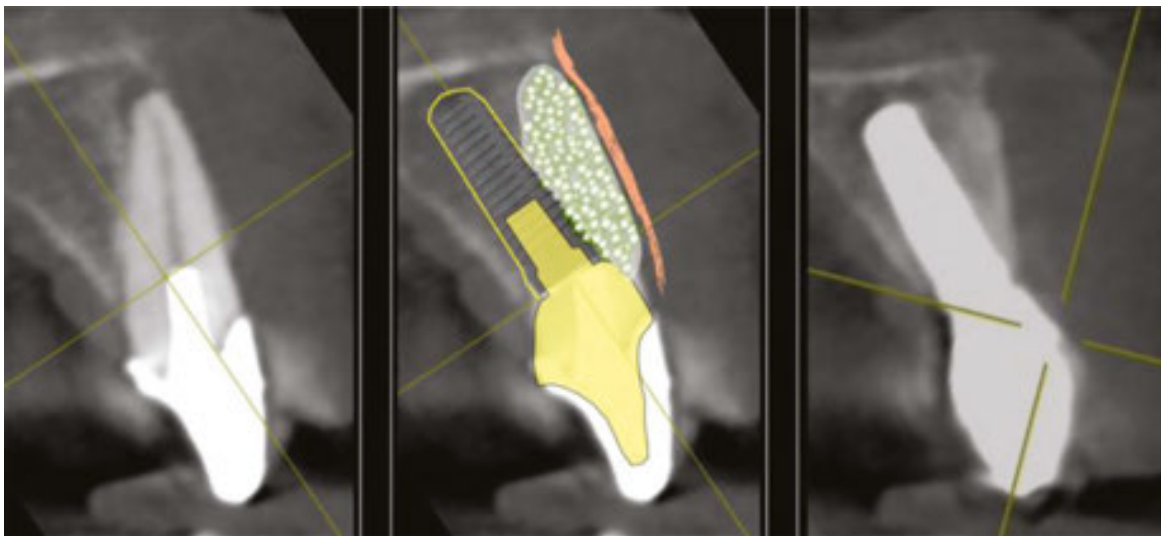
On the right is a cross-sectional CBCT slice taken 6 months following treatment showing that the labial region is stable and has filled in nicely.
